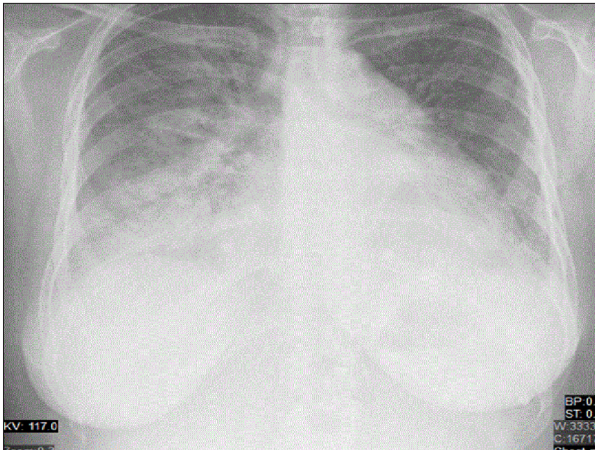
Chest radiograph at admission. Chest X-ray revealed cardiomegaly, increased vascular marking, congested lung fields, and cephalization of pulmonary vasculature, in addition to right middle- and lower-lobe patchy opacities.
